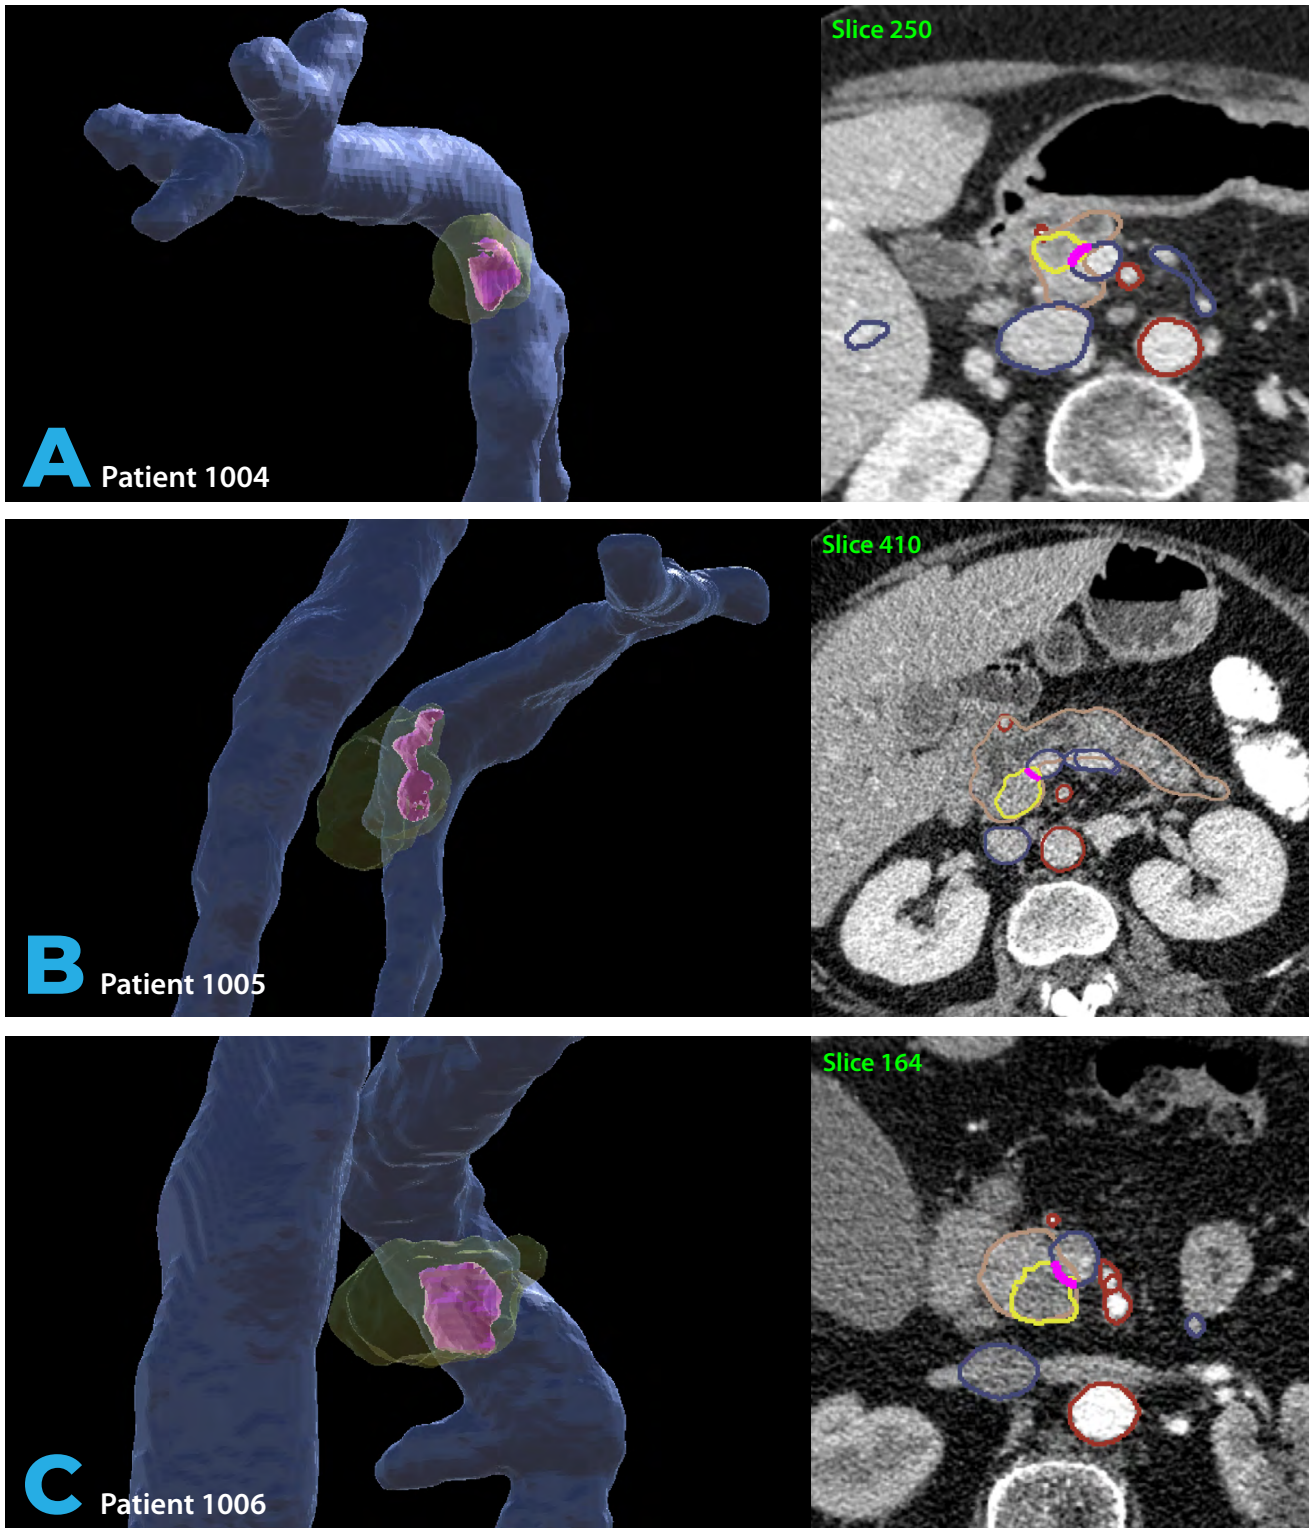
Tumour footprints highlighted on three-dimensional reconstructed portal vein – superior mesenteric vein and the corresponding CT slice. (A) Patient case 4; (B) Patient case 5; (C) Patient case 6. Blue = veins; red = arteries; yellow = tumour; pink = tumour footprint; light brown = pancreas.
